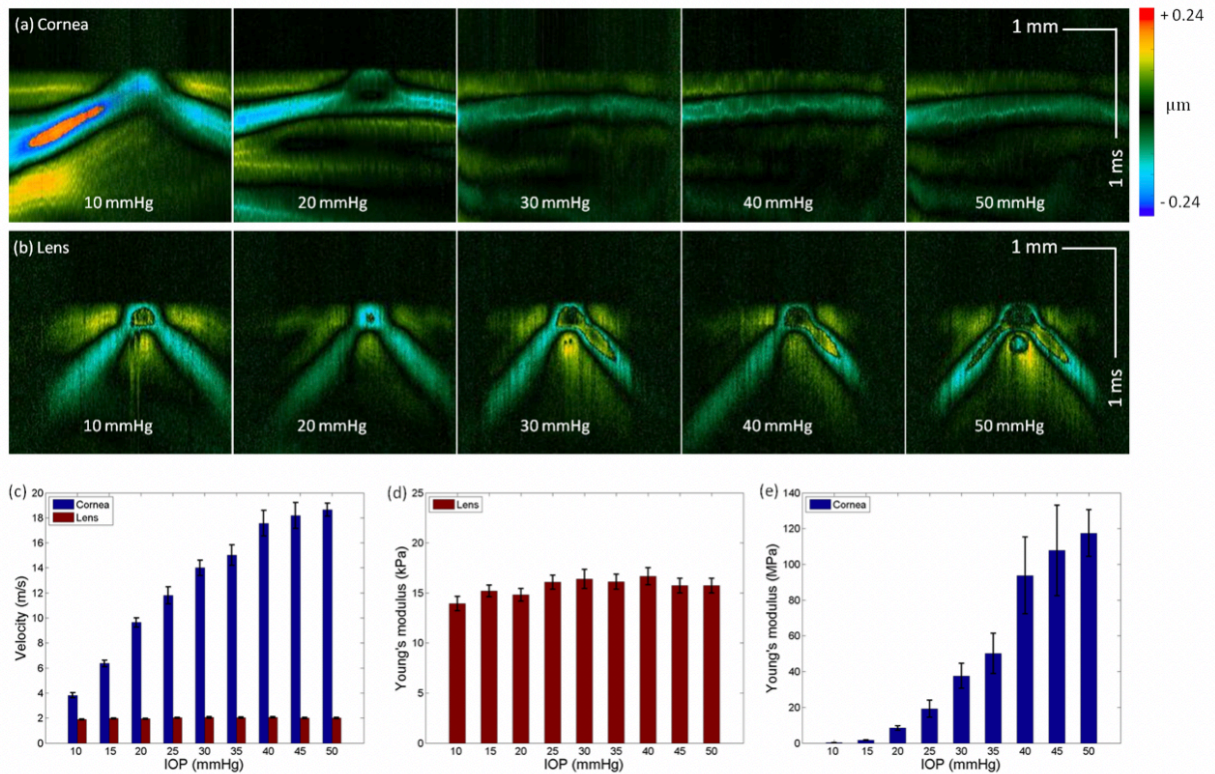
In vivo IOP experiments using a 12-week rabbit. (a-b) Spatiotemporal Doppler OCT of the cornea and lens, respectively, at different IOPs. (c) Elastic wave velocities in the cornea and lens. (d) Young's modulus of cornea as a function of IOP. (e) Young's modulus of lens as a function of IOP.
